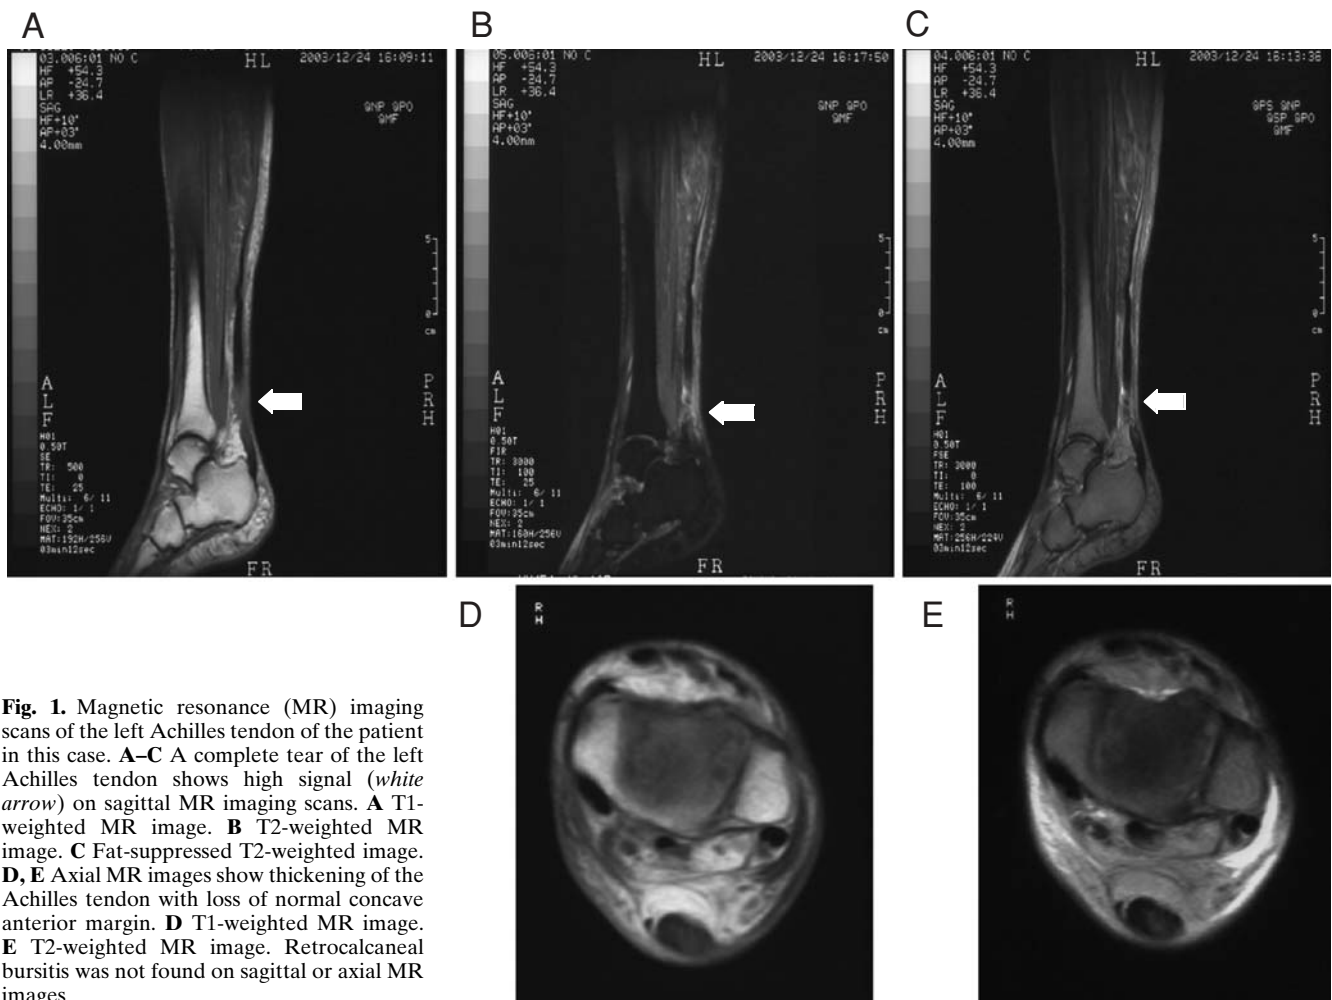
Magnetic resonance (MR) imaging scans of the left Achilles tendon of the patient in this case. A–C A complete tear of the left Achilles tendon shows high signal (white arrow) on sagittal MR imaging scans. A T1-weighted MR image. B T2-weighted MR image. C Fat-suppressed T2-weighted image. D, E Axial MR images show thickening of the Achilles tendon with loss of normal concave anterior margin. D T1-weighted MR image. E T2-weighted MR image. Retrocalcaneal bursitis was not found on sagittal or axial MR images
